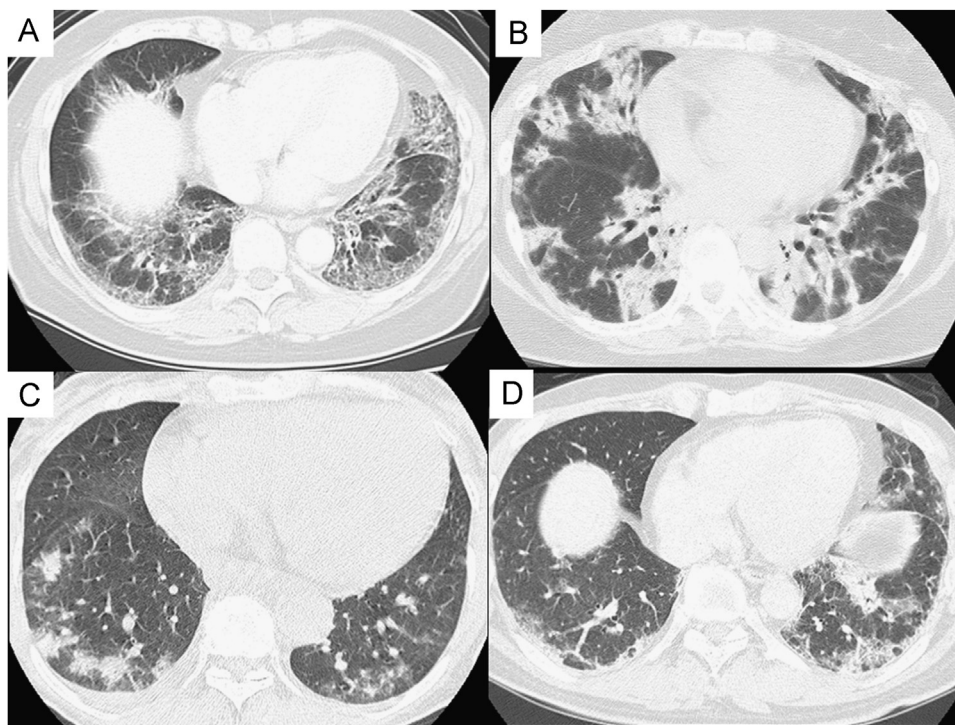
HRCT features. Representative HRCT images. (A) An image of the lower lung zones of a 59-year-old woman without anti-ARS-Ab and anti-MDA5-Ab. This was classified as the NSIP pattern showing characteristic ground-glass opacities with dilated air bronchogram (or bronchiologram) showing peribronchovascular and subpleural distribution. (B) An image of the lower lung zones of a 51-year-old woman with anti-Jo-1-Ab and without anti-MDA5-Ab. This was classified as the NSIP with OP pattern showing characteristic consolidations and ground-glass opacities with dilated air bronchogram (or bronchiologram) showing peribronchovascular distribution. (C) An image of the lower lung zones of a 68-year-old woman without anti-MDA5-Ab and anti-ARS-Ab. This was classified as the OP pattern showing patchy consolidations without architectural distortion. (D) An image of the lower lung zones of a 50-year-old man with a high titer of anti-MDA5-Ab without anti-ARS-Ab. This was considered to be the unclassifiable CT pattern with consolidations and ground-glass opacities showing peripheral and subpleural distribution with architectural distortion. HRCT: high-resolution computed tomography; anti-ARS-Ab: anti-aminoacyl-transfer RNA synthetase antibody; anti-MDA5-Ab: melanoma differentiation-associated gene 5 antibody; NSIP: non-specific interstitial pneumonia; OP: organizing pneumonia.
